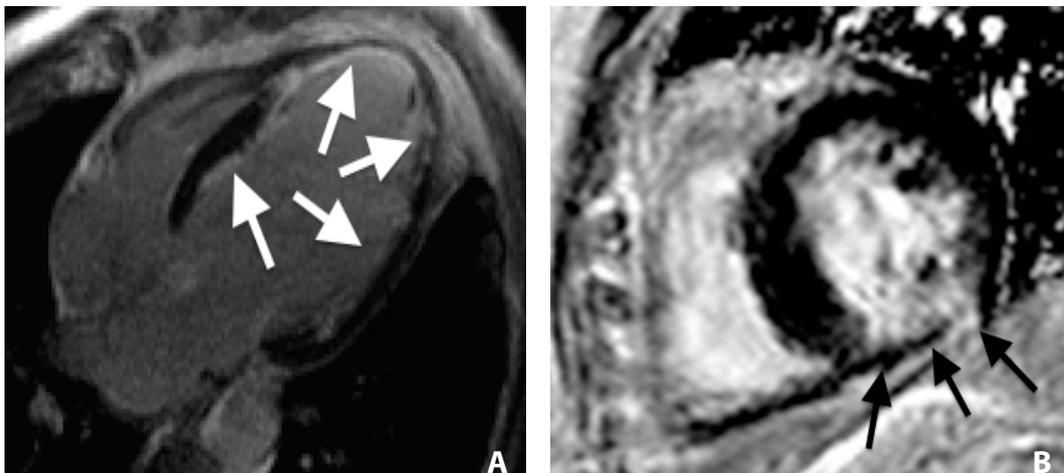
Delayed-enhancement MRI study. A) Four-chamber image showing diffuse subendocardial enhancement in the left ventricular myocardium (arrows), from coronary artery disease. B) Short-axis image showing transmural enhancement in the left ventricular inferior wall (arrows), from myocardial infarction.
